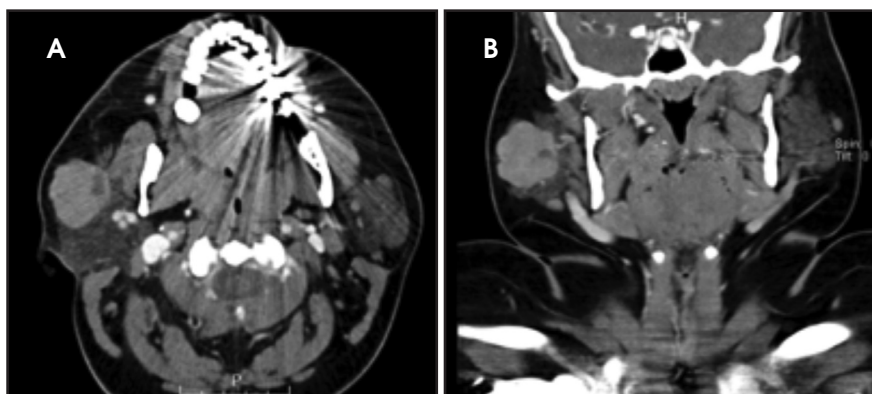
(A) Axial CT neck with IV contrast demonstrates right parotid mass. (B) The mass is again demonstrated in the coronal plane.
